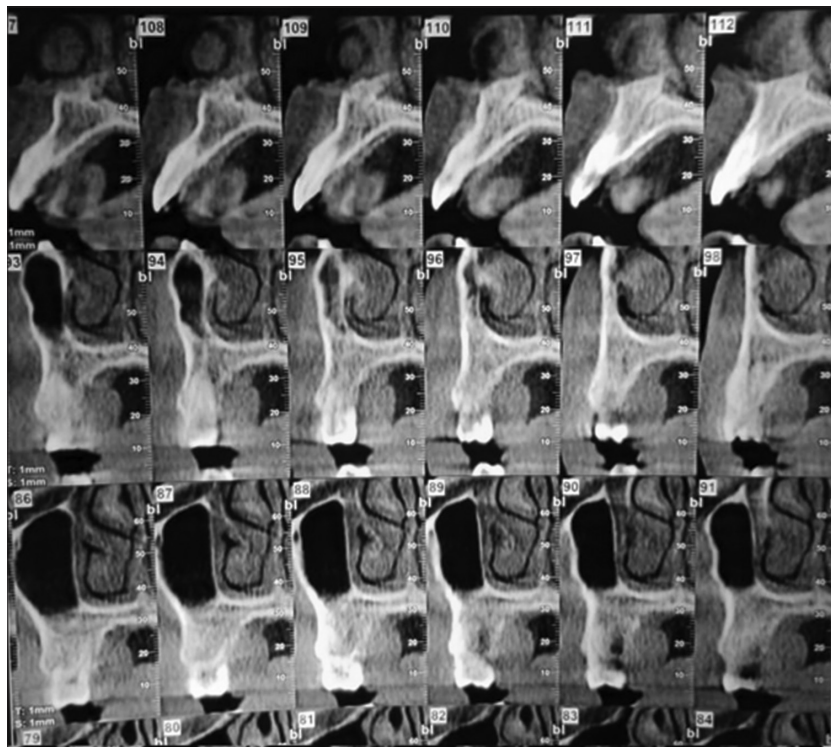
CBCT coronal view
